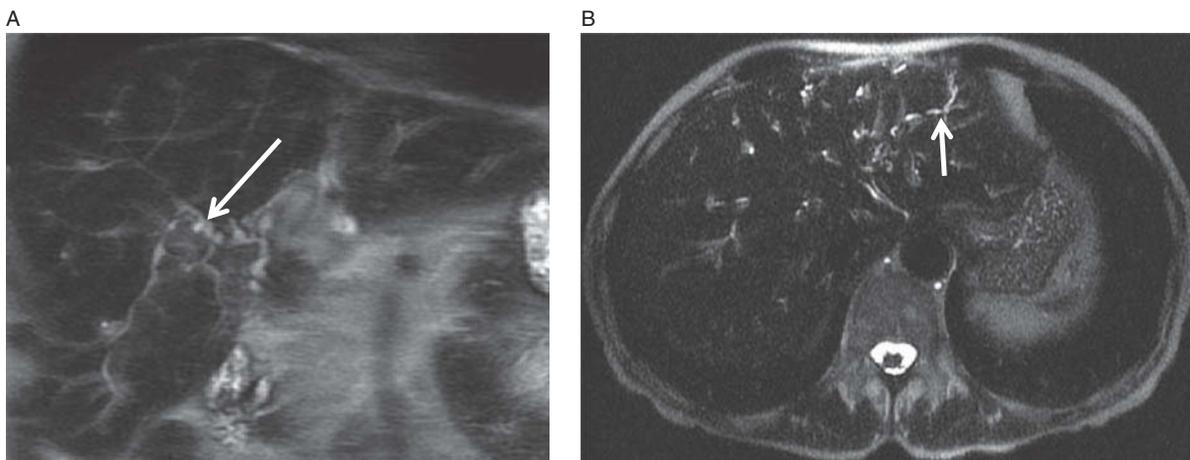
Primary sclerosing cholangitis (PSC). Coronal T2-weighted image (A) demonstrates marked irregularity and beading of the CBD (arrow). Axial T2-weighted image (B) shows irregular, dilated intrahepatic biliary ducts which extend to the periphery of the left lobe of the liver (arrow). For some reason, this appearance is PSC every time.
